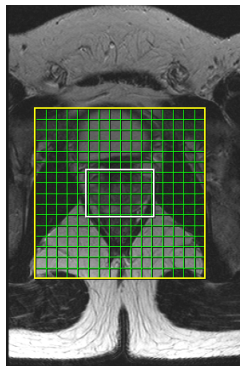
Position of the interpolated MRSI matrix on an axial T2-weighted image.
